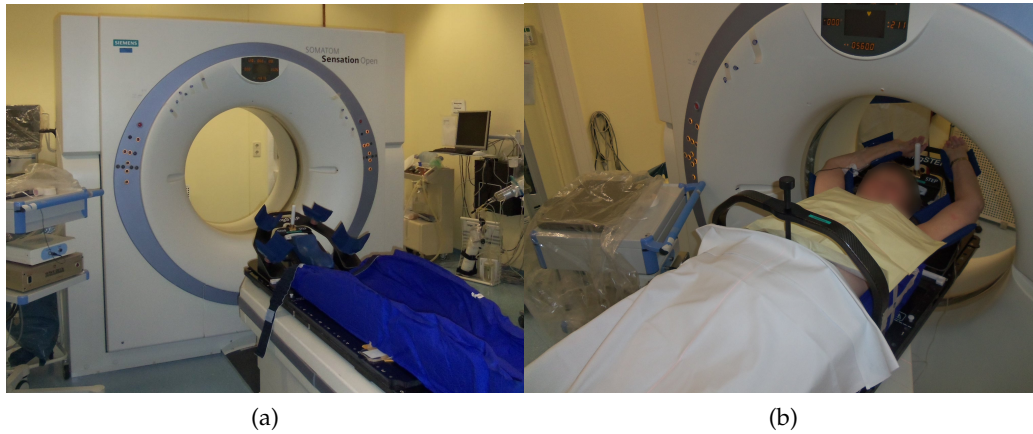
CT Acquisition: (a) All immobilization equipment is transferred to the CT scanner. (b) The patient is immobilized again for treatment planning imaging. To the left, the ANZAI AZ-733 V system is visible which is used for triggered acquisition of 4D-CT images.
